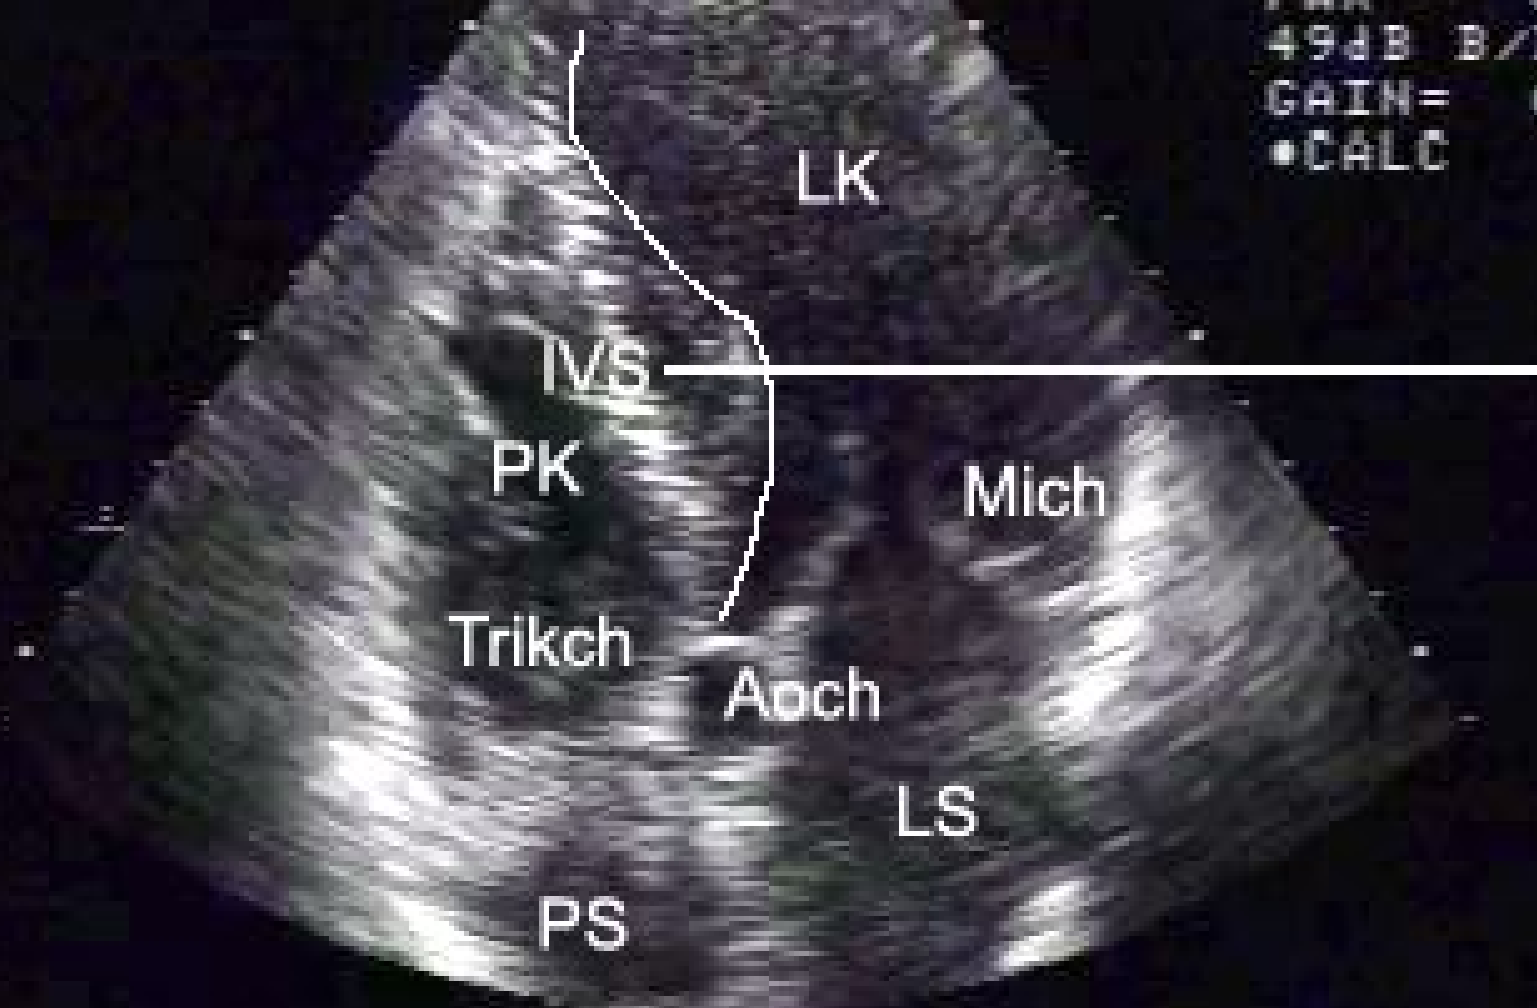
Two-dimensional transthoracic echocardiographic image in the apical four-chamber view of a patient with hypertrophic cardiomyopathy showing severe left ventricular hypertrophy. LV = left ventricle, LA = left atrium.
